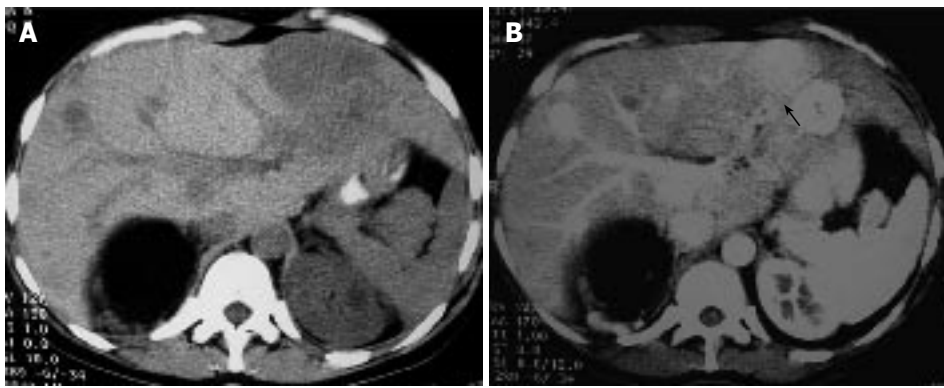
A: Unenhanced transverse CT scan demonstrates multiple hypodense masses located on both liver lobes. Fatty tissue (known angiomyolipoma) replaces the most of the upper pole of the right kidney; B: Post-contrast CT scan depicts multiple round liver lesions, with a smooth margin, which demonstrate intense homogeneous enhancement. The lesion located in segment three, has a small central area of hypodensity, consistent with a central scar.
